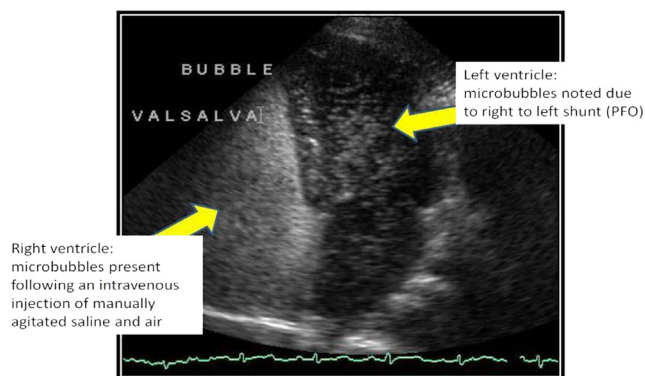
Echocardiographic still image: intravenous injection of manually agitated saline in a patient with a marked right-to-left cardiac shunt. Note the blush of agitated saline in the left ventricular chamber. Study performed October 30, 2012. Image provided by Michael Main, MD (St. Luke's Mid America Heart Institute, Kansas City, Missouri).
